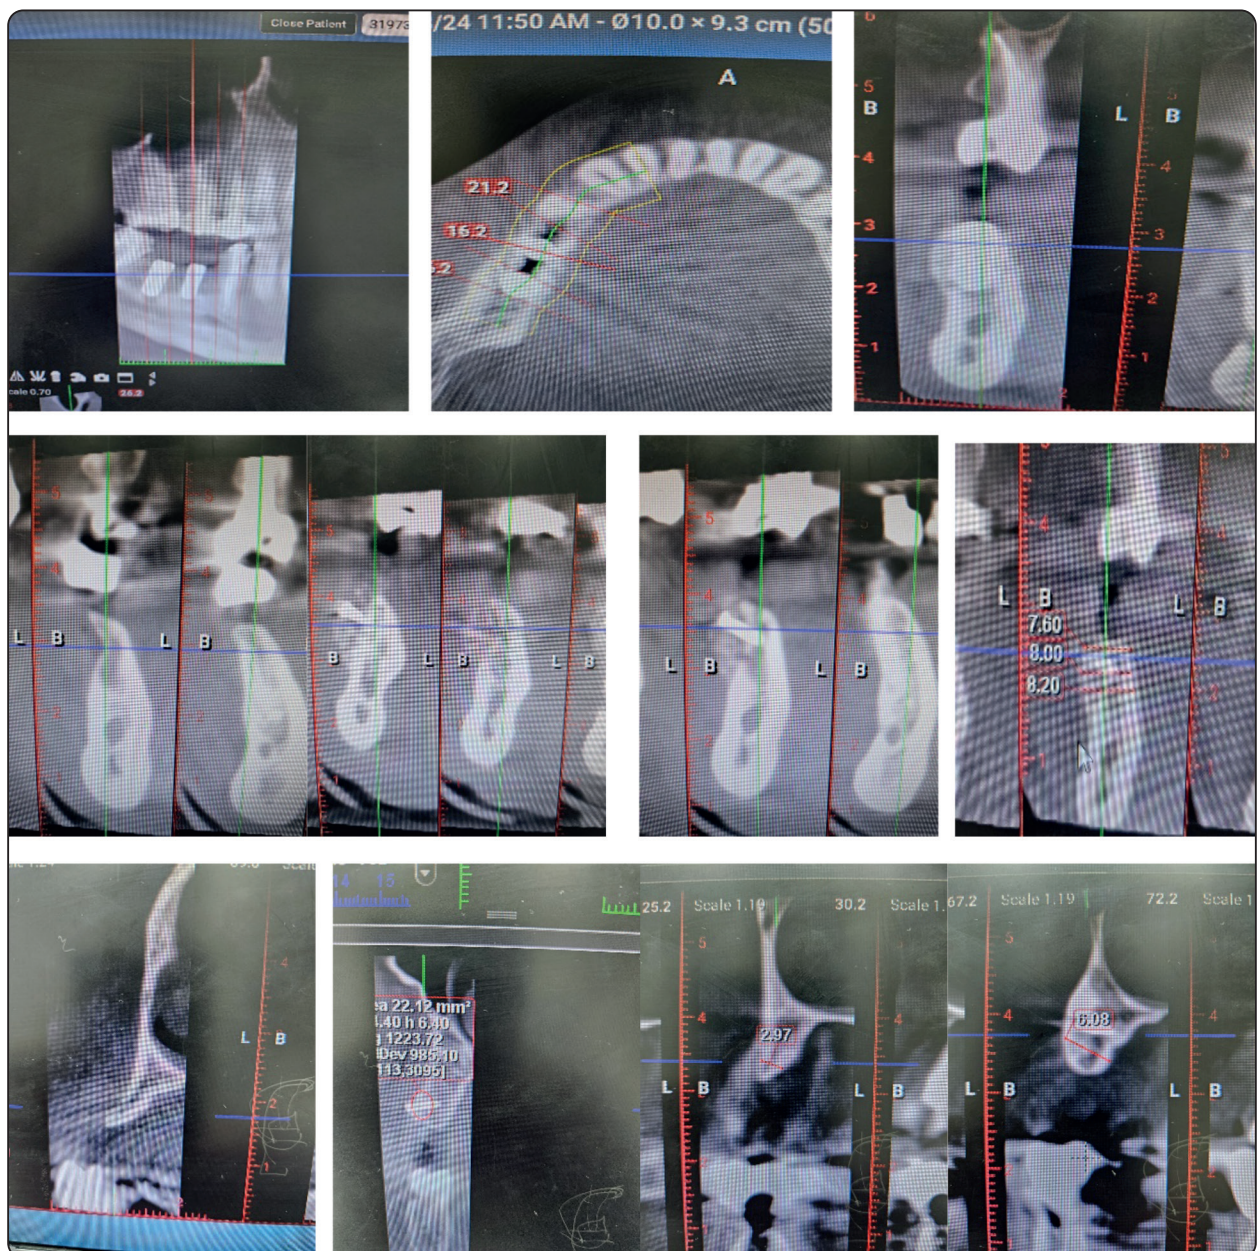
Showing the radiographic images of pre and postoperative images of some of the cases included in the study
